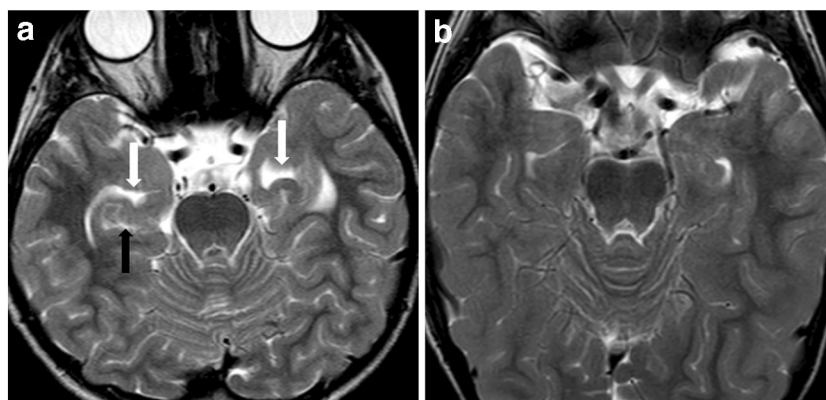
Abnormal triangular shape of the temporal horn in an 11-year-old girl with achondroplasia. a Axial T2-weighted MR image (repetition time/echo time [TR/TE]: 5,500/100 ms) shows triangular shape of the temporal horns of the lateral ventricles (*white arrows*). Note the deep
